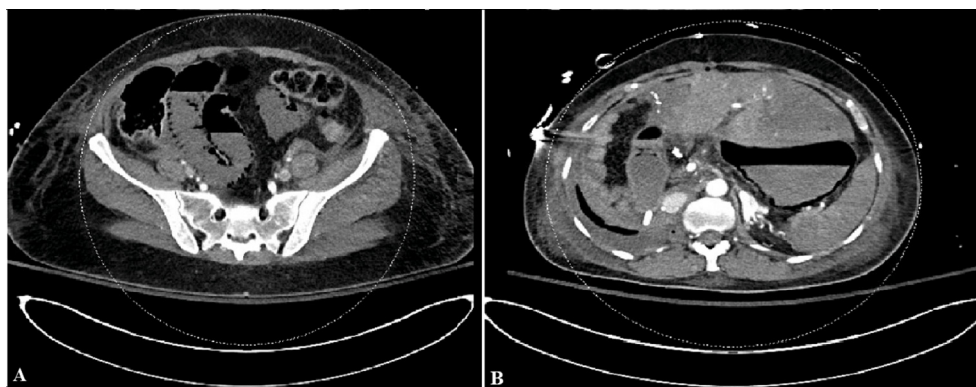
Axial enhanced CT scan of the abdomen shows extensive pneumatosis involving throughout the small bowel folds (A) as well as the wall of the stomach (B) in keeping up with advanced bowel ischemic changes.
